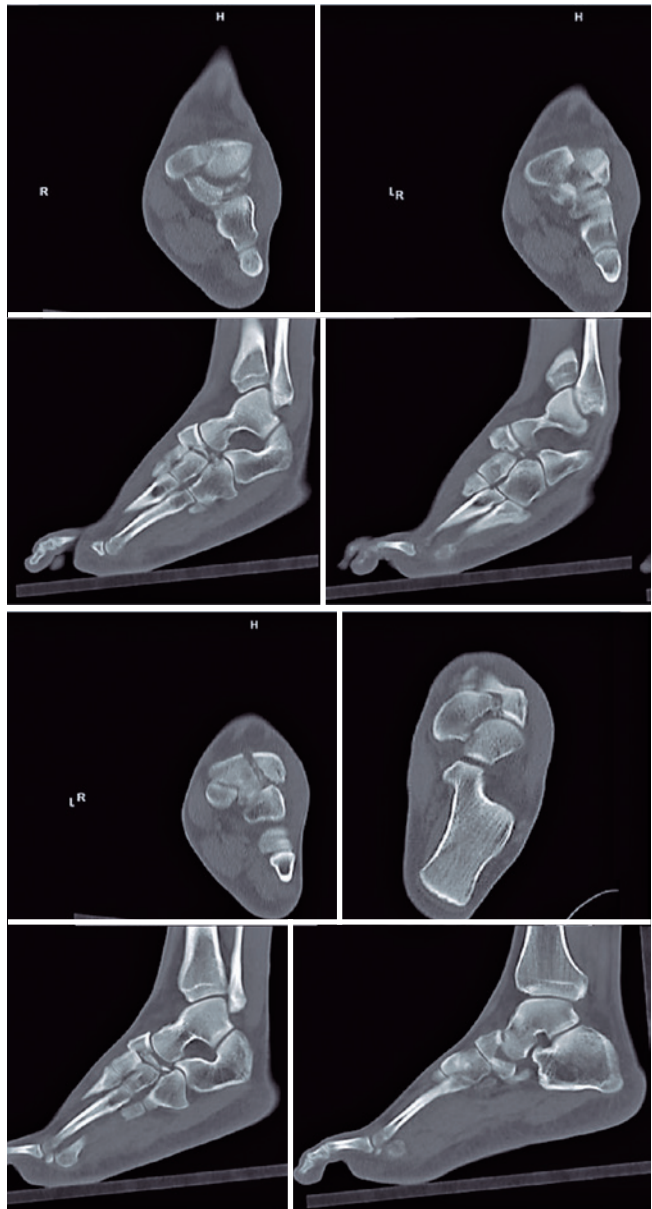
Computed tomography scans on the coronal, axial, and sagittal views showing the dorsomedial fragment displaced dorsally, with impaction of the dorsomedial articular surface of the talonavicular joint, and the plantar-lateral fragment comminuted and displaced, with shortening of the medial column of the midfoot.
